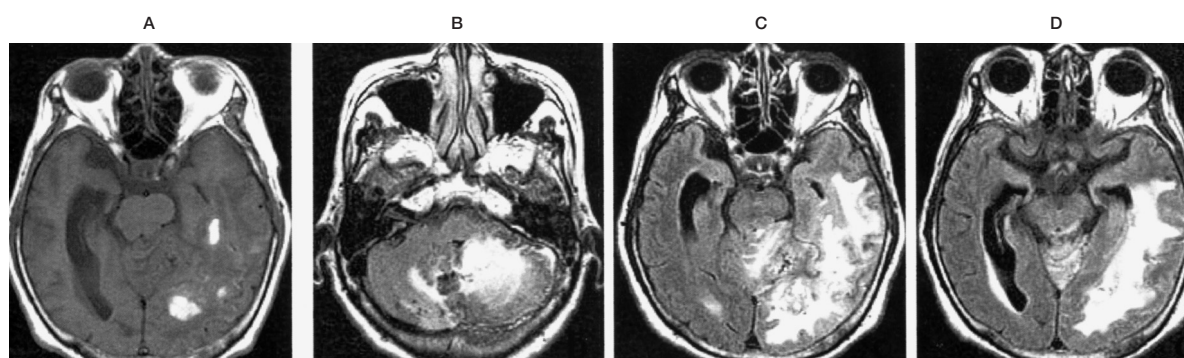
Case 5: 66 y.o. female. Her chief complaints were disturbance of consciousness and aphasia. MRI (T1WI) shows hematoma in left occipital and temporal lobe (A). There is vasogenic edema because of venous congestion in left cerebellar hemisphere (B), left temporal lobe and left occipital lobe (C,D).
